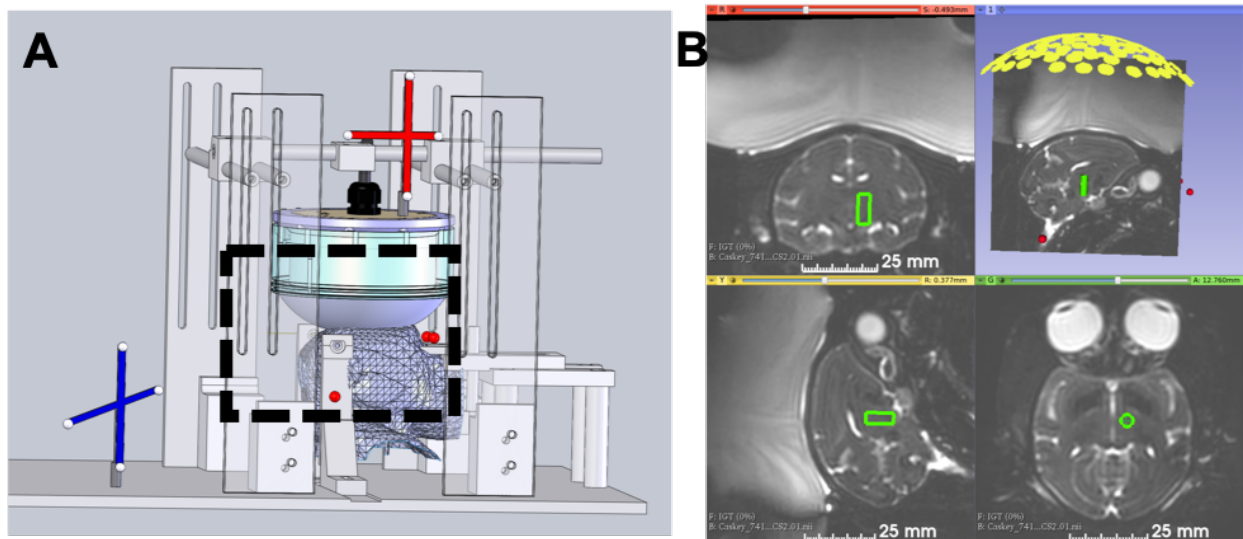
A: A model of the physical set up of the optically tracked NHP experiment. The NHP is placed on a custom table for MR imaging and the head fixed in place with a frame. The FUS transducer is placed over the head on a frame built into the table. The transducer has an optical tracker placed on the back and a water bubble on allows for ultrasound coupling. Fiducials are placed on the ear bars and eye bars of the frame (red spheres). A reference tracker is fixed to the table for optical tracking. MR coils are placed on either side of the head (not pictured). The black dashed region is the approximate MR imaging region. B: The 3D Slicer view of the NHP experiment. The optically tracked focus model is shown with the green cylinder. Fiducial markers (red spheres) can be localized and registered to the physical marker locations. The individual elements of the transducer can be visualized in the MR space.
